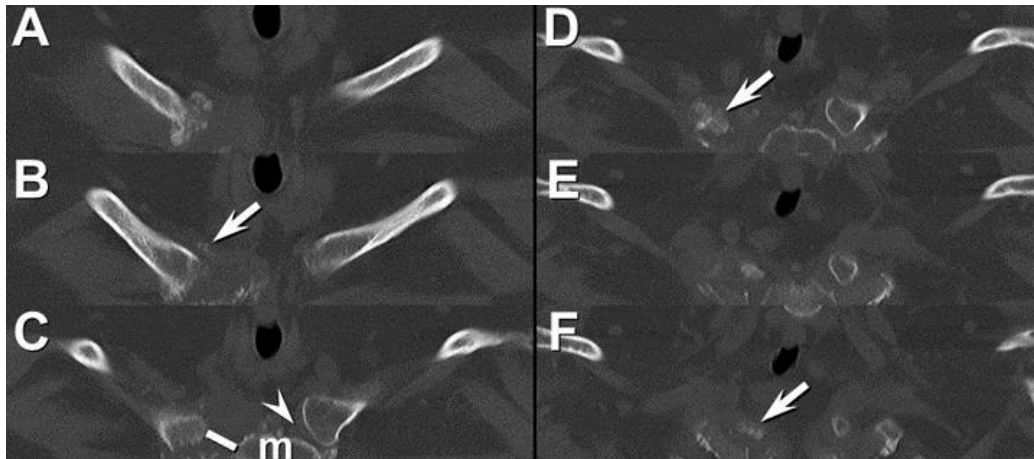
Coronal maximum intensity projection images from a dual-energy thoracic CT study again show destructive changes centered on the right sternoclavicular joint, evidenced by periosteal reaction and osseous destruction and fragmentation (arrow) associated with widening of the right sternoclavicular joint space (line in C) compared with the normal sternoclavicular joint space on the left (arrowhead). m= manubrium.
